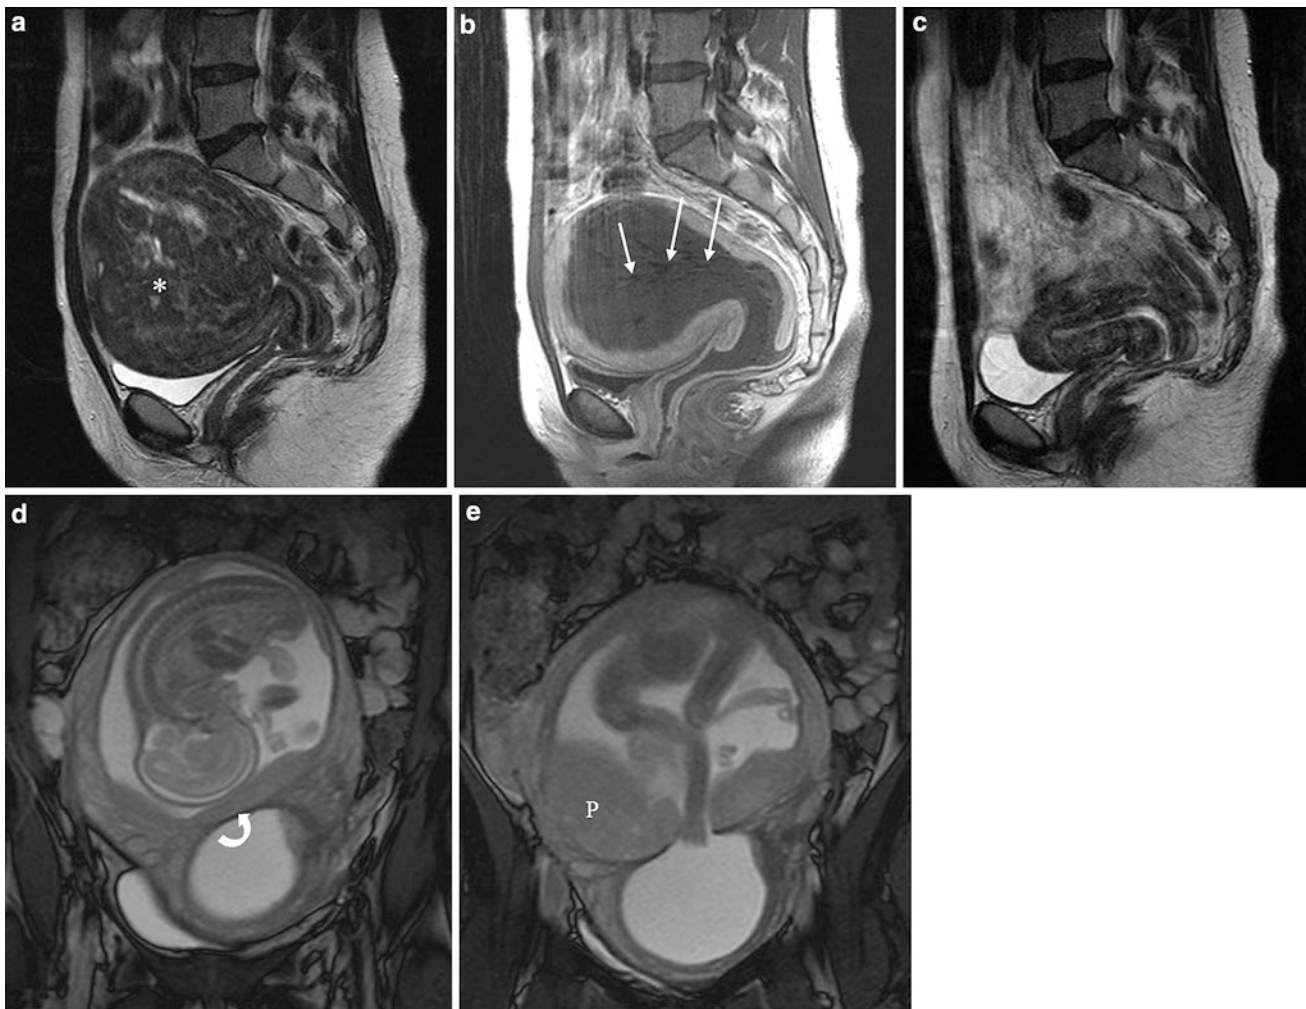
Sagittal T2 weighted MRI (a) before UAE showing large intracavitary fibroid (*). b Contrast-enhanced T1FS MRI performed 3 months after UAE. The uterine cavity is still expanded by the fibroid which is now completely de-vascularised and non-enhancing. There are linear areas of signal void within the fibroid in keeping with gas within the degenerated fibroid (arrows). c Sagittal T2 weighted MRI performed 18 months after UAE. The patient clinically passed the fibroid and there is restoration of a normal looking uterine cavity. d and e coronal True-FISP MRI. The patient is 21 weeks pregnant.
